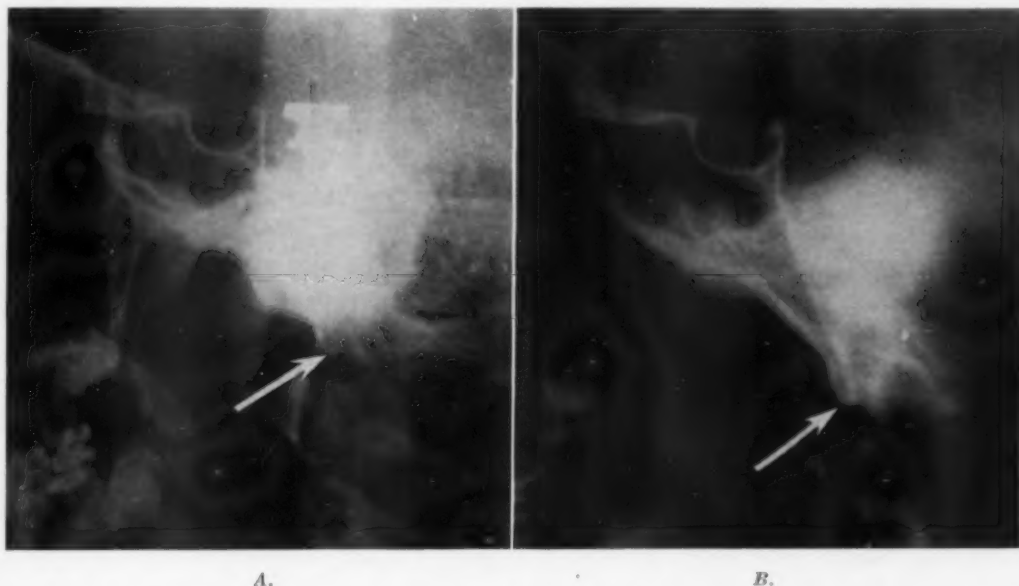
Lateral cephalometric roentgenogram (A) and midsagittal laminagram (B) of same person, showing location of basion.
